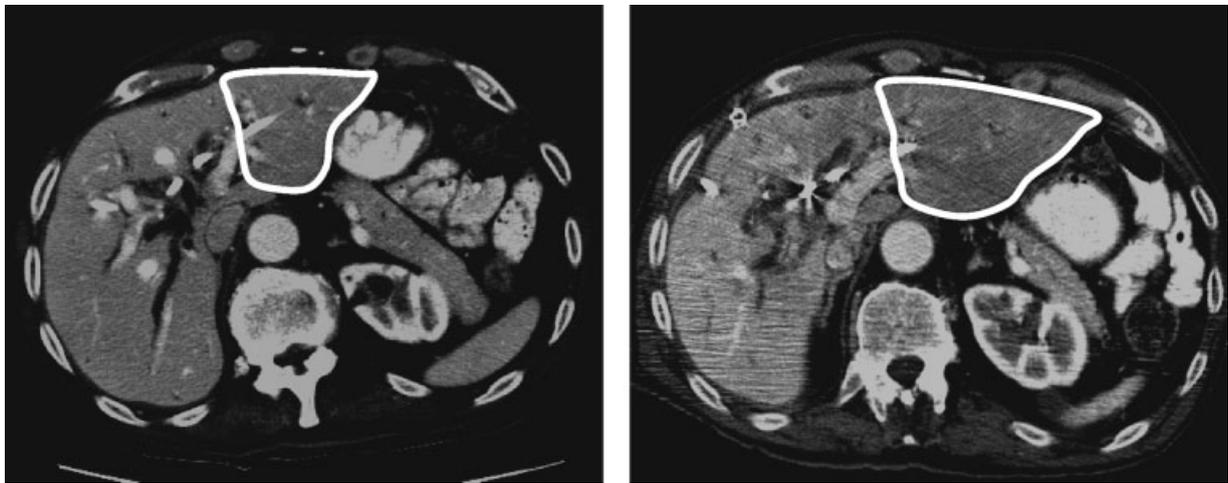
Portal phase of thin-cut computed tomograms in a patient with hilar cholangiocarcinoma before (left panel) and after (right panel) right trisectoral portal vein embolization (PVE) (embolization of segment IV and the right liver). Outlined is the future liver remnant, which increased in volume from 11 to 26% of the standardized total liver volume. Atrophy and arterialization of the right liver are apparent after PVE. Extended right hepatectomy with total caudate lobectomy was performed with negative margins and no postoperative hepatic dysfunction. The patient was discharged from the hospital on postoperative day 9.
